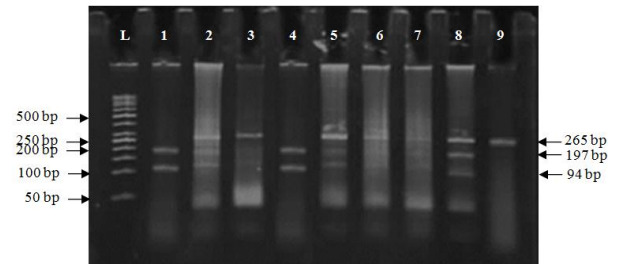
RFLP analysis of C677T mutation in healthy control subjects detected by 8% native poly acrylamide gel electrophoresis (PAGE). The 265 bp PCR product was digested with *HinfI*. Lane L: GeneRuler 50 bp DNA ladder (Fermentas # SM0371); lane 3 and 6: CC homozygous (265 bp), lane 2, 5, 6 & 8: CT heterozygous mutation (94 bp, 197 bp, 265bp); lane 1 & 4: TT homozygous mutation (94 bp, 197 bp).
